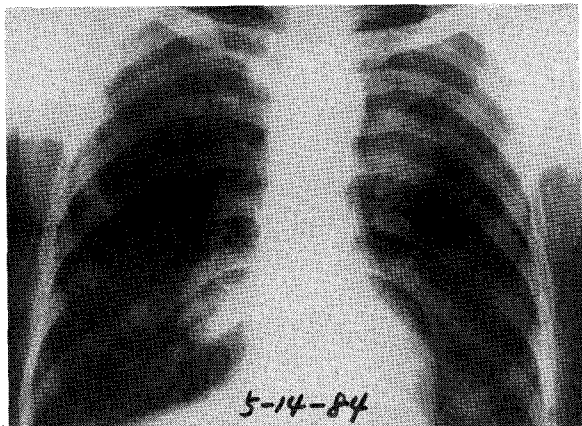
Post radiation X-rays of case 4 show marked regression.
